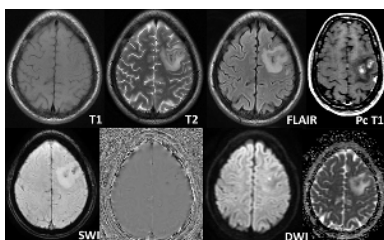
Axial MR images of brain of the patient showing T1 isointense and T2/FLAIR hypointense contents in sulcal spaces along
